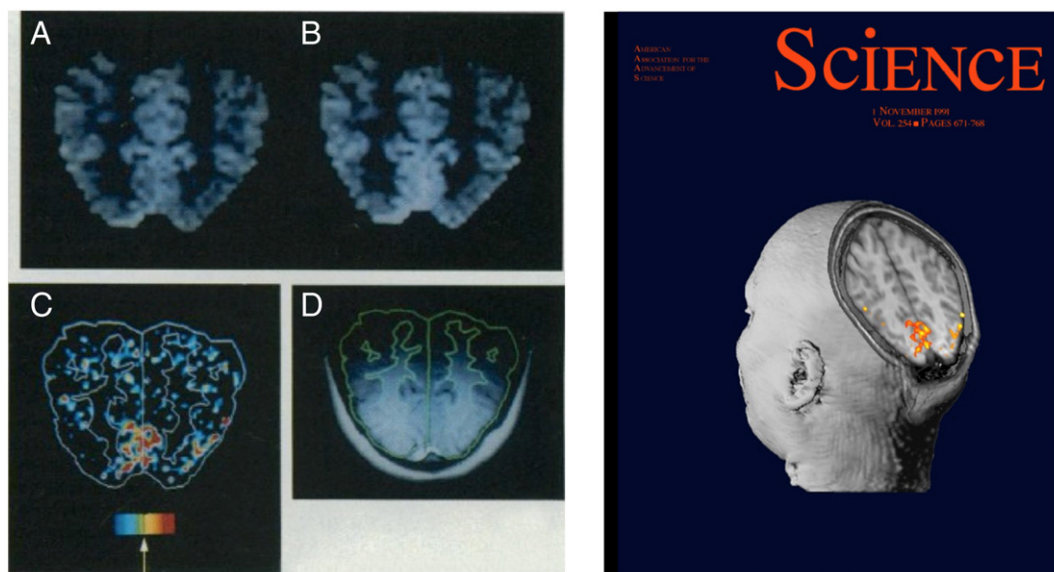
On the left, the subtraction images associated with the first CBV changes, as measured with MRI, associated with neural activity. On the right, the cover of the issue of *Science* in which the figure appeared. A and B are CBV maps obtained when photic stimulation was OFF or ON, respectively; C is the pseudo-colored subtraction image between “A” and “B” with warmer colors indicating more activity in the ON condition; D is “C” superimposed on a structural MR image of the anatomy.
